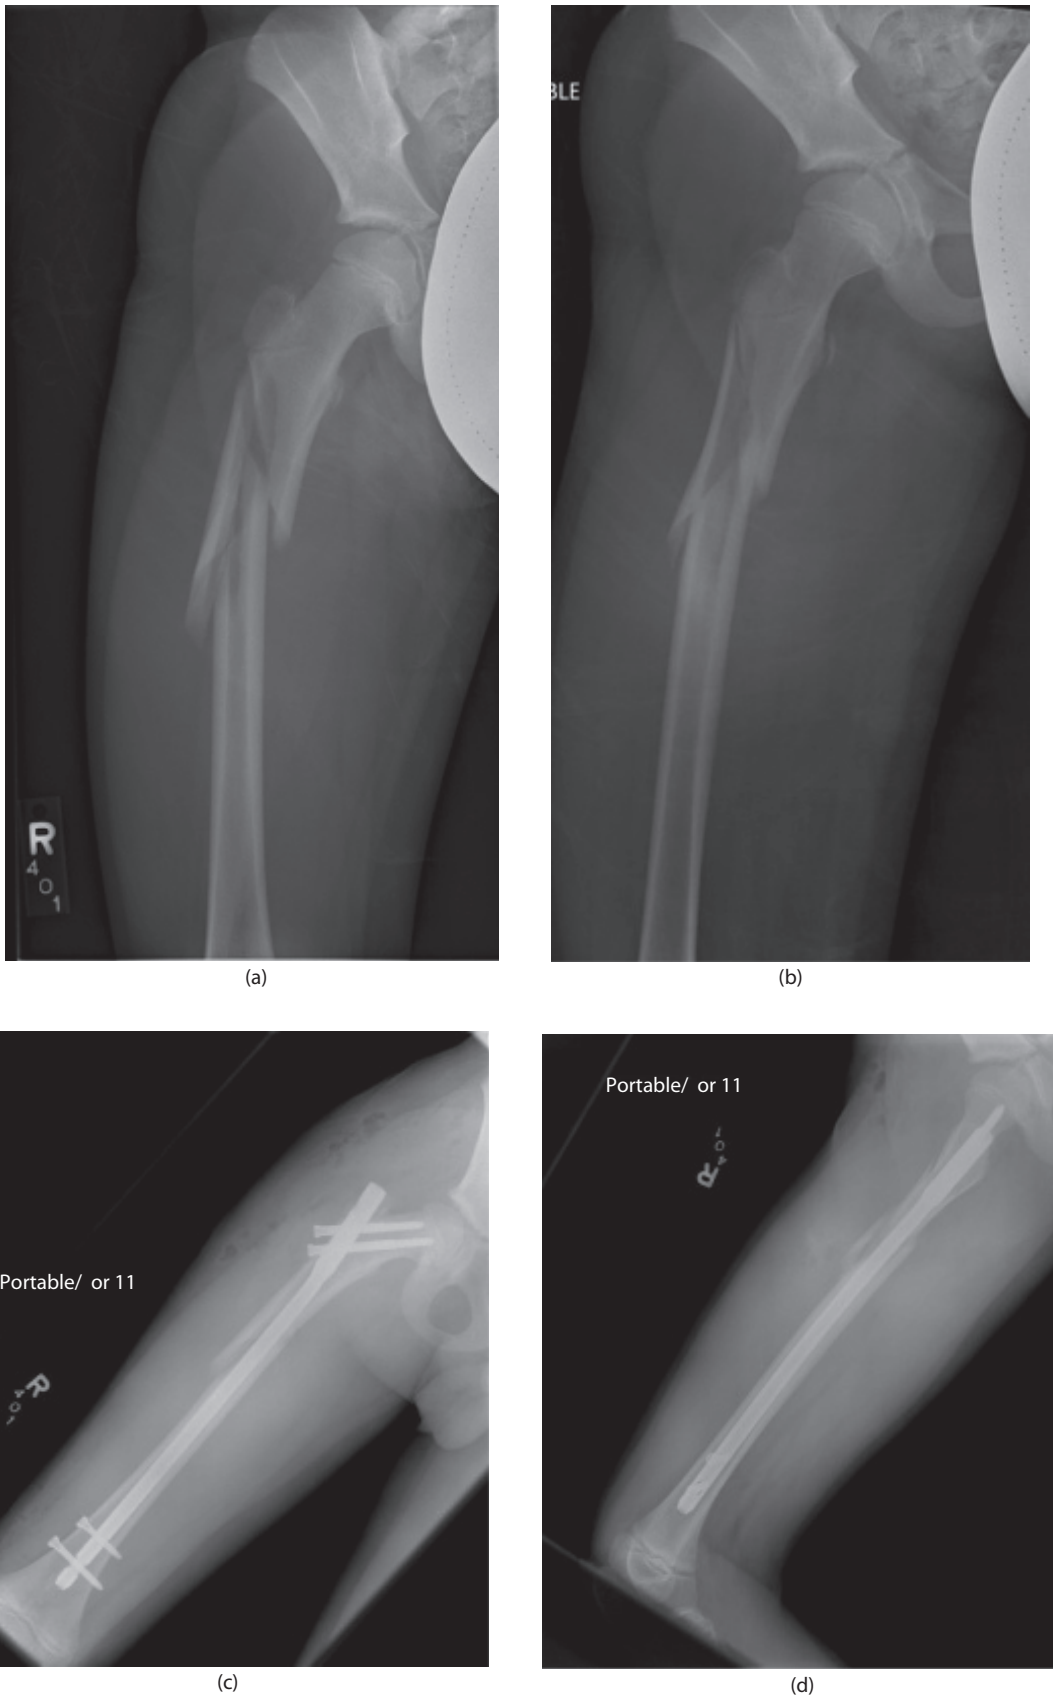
(a) and (b) Radiographs of a 12-year-old male who sustained a comminuted subtrochanteric femur fracture after falling from his bicycle. (c) and (d) Radiographs showing treatment of his fracture with a rigid locked intramedullary nail.
